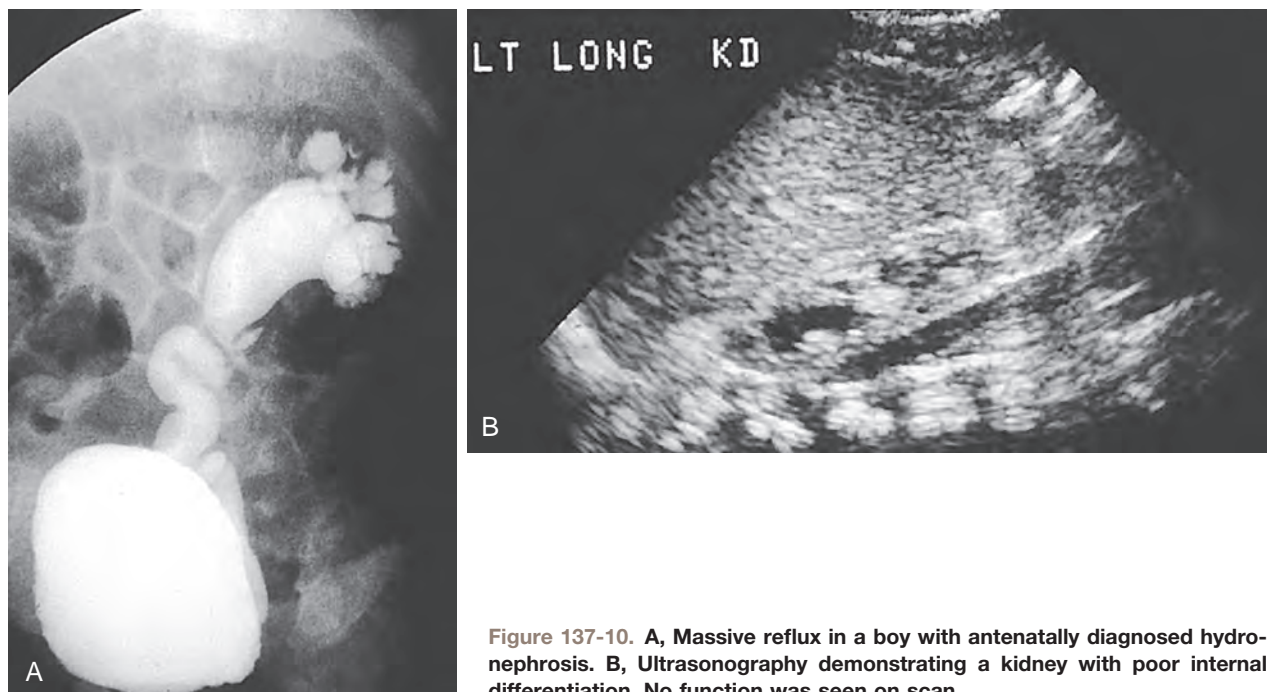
A, Massive reflux in a boy with antenatally diagnosed hydronephrosis. B, Ultrasonography demonstrating a kidney with poor internal differentiation. No function was seen on scan.
